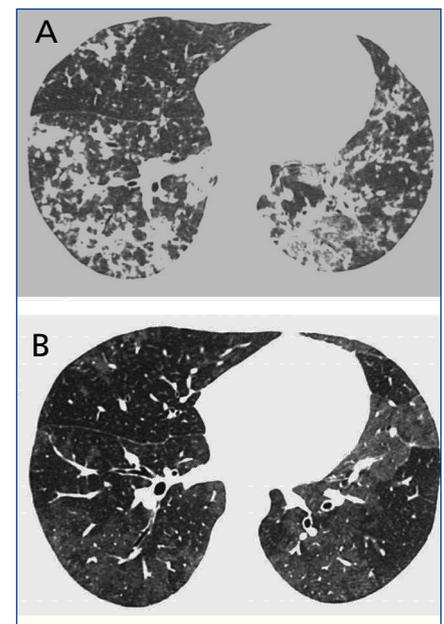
High-resolution CT at the level of the lower lobes (A) (obtained at the time of clinical presentation when respiratory symptoms were evident) demonstrates areas of non-homogeneous air space consolidation in the lower lobes, and mild ground-glass opacities. Follow-up scan (B), taken in the same plain as A, and 30 days after discontinuation of sirolimus, showed a reduction in the air-space consolidation pattern, with bilateral areas of residual ground-glass attenuation. The expiratory scans did not show air trapping.
